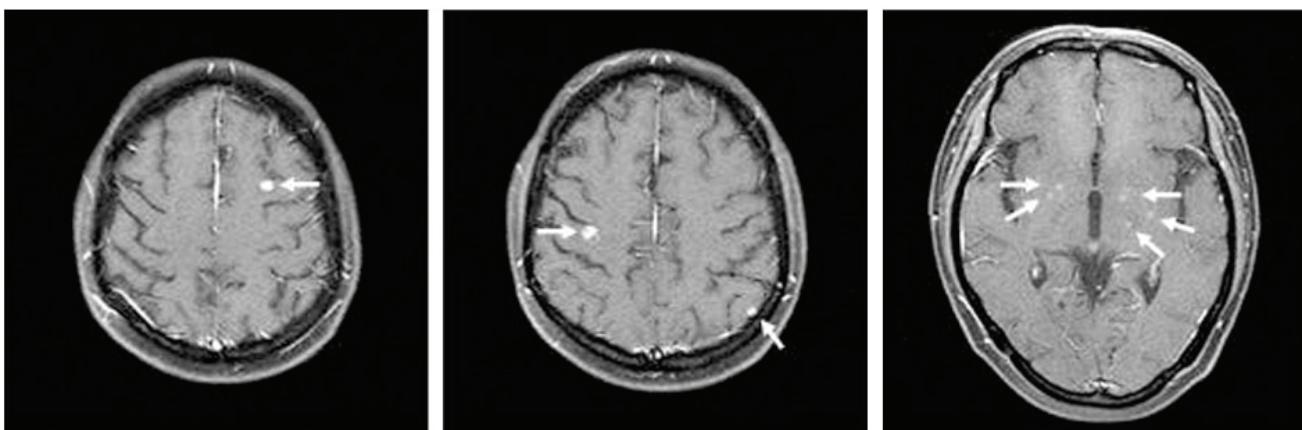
Magnetic resonance imaging of the brain showing multifocal, ill-defined nodular enhancing lesions in both cerebral hemispheres and basal ganglia.
